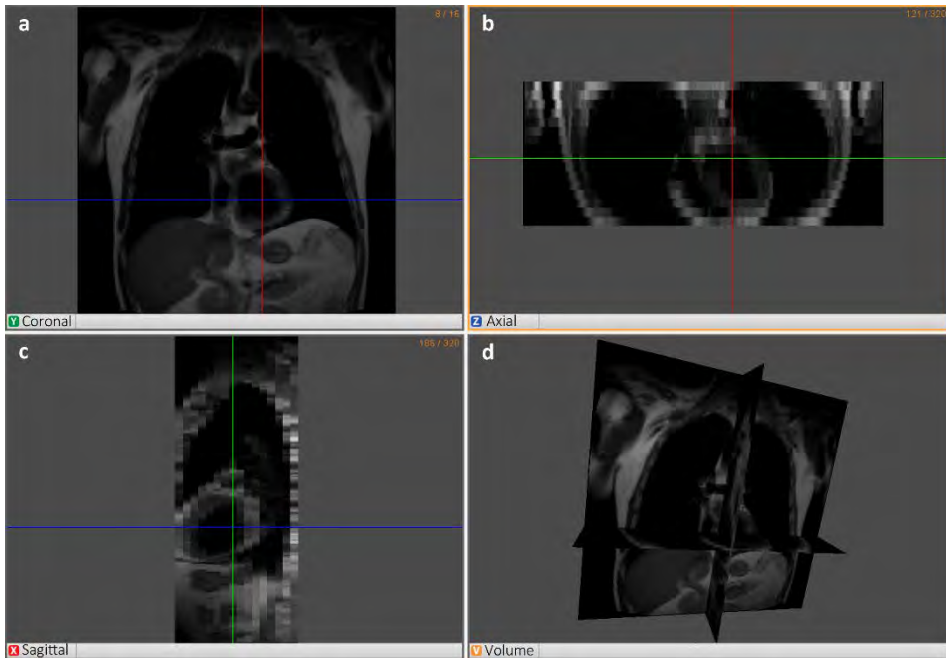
Whole-torso anatomical MRI. Views of MRI slices in standard planes: (a) coronal, (b) axial and (c) sagittal planes and (d) 3D view of orthogonal standard planes.
